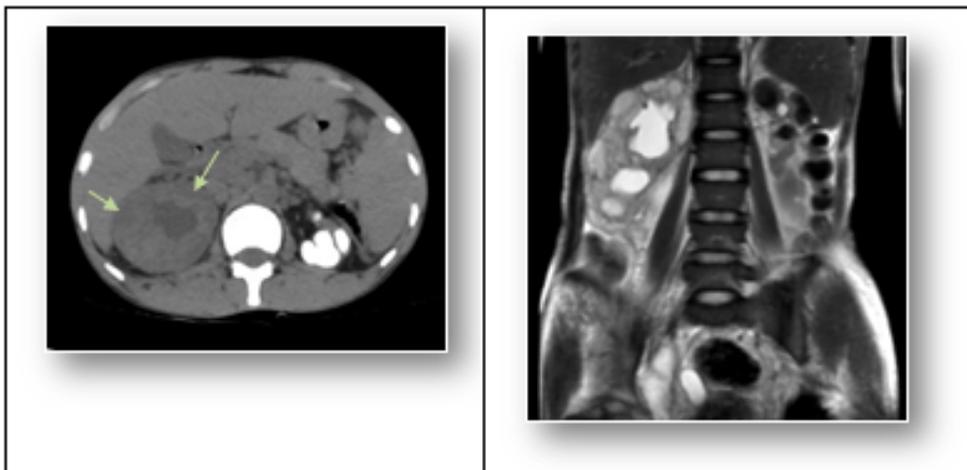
Axial plain CT image of the same patient showing multiple peripherally located hypodense lesions (arrows) on right side most like s/o multiple subcapsular abscesses with moderate right hydronephrosis. Lobar calcification is noted in left kidney. Only plain study was done as patient's Serum creatinine levels were high. These findings on right side were clearer in Coronal T2-W MRI images without administration of any contrast, showing multiple subcapsular abscesses and moderate right hydronephrosis. The left kidney is replaced by multiple lobar calcifications i.e. putty kidney.
